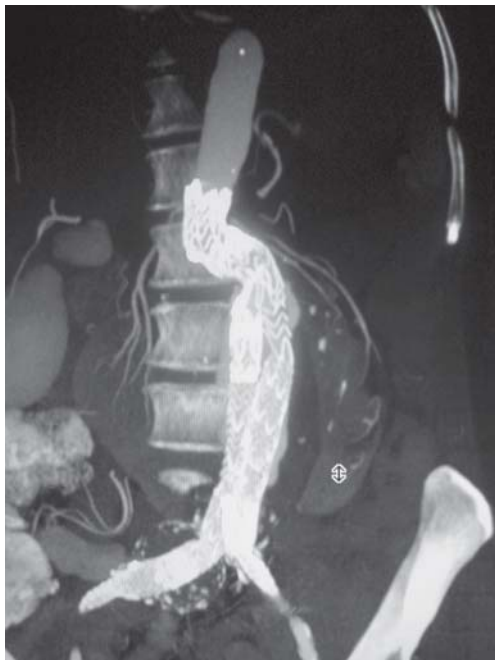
Post operative CT scan showing exclusion of the AAA and right iliac aneurysm and no endoleaks
